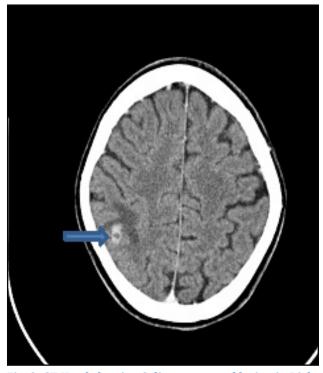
CT Head showing Solitary encysted lesion in Right parietal lobe with peripheral enhancement on without perilesional edema s/o Solitary NCC lesion.
